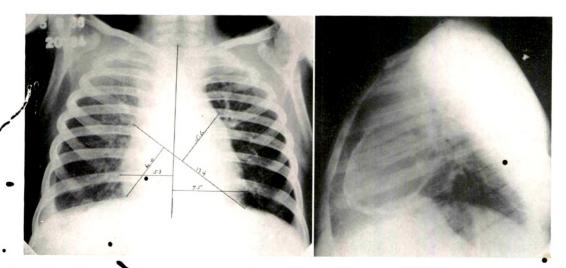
(left). Posteroanterior roentgenogram of chest. There is an increase in diameter of the base of the heart but no increase in the transverse diameter. There is increase in the transverse diameter of the supracardiac shadow due to dilated superior vena cava. There are congested pulmonary vessels, with pleural thickening and effusion. Calcification not discernible with the usual exposure in this projection.
